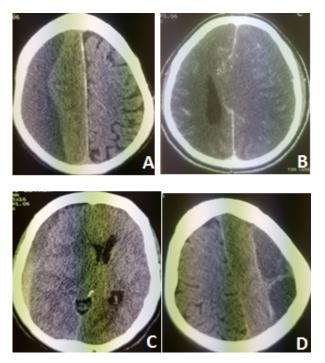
Axial slice brain CT, parenchymal window demonstrating a right hemispheric chronic subdural hematoma in (A), a left fronto-parietal isodense chronic subdural hematoma in (B), a right fronto-parietal chronic subdural hematoma with rebleeding in (C), and a left parieto-frontal partitioned chronic subdural hematoma in (D).
